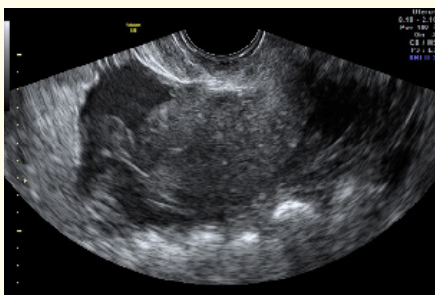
Ultrasound scan of free pelvic fluid in tubal pregnancy at 7 weeks' gestation.
